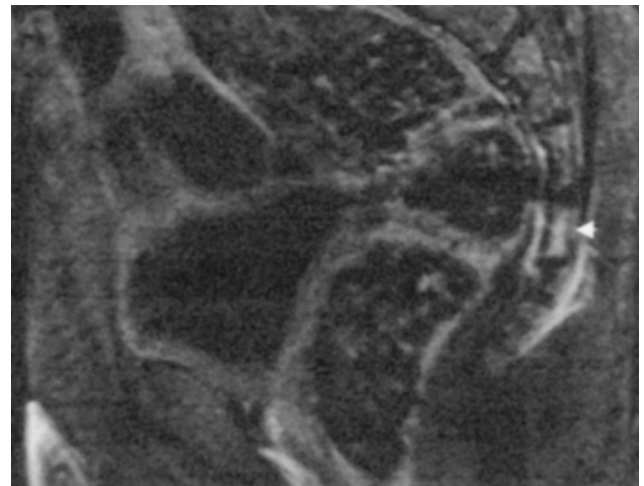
A follow-up T1-weighted magnetic resonance image with gadolinium confirmed the diagnosis of osteomyelitis of the lower sacral segment S5 (white arrowhead).
